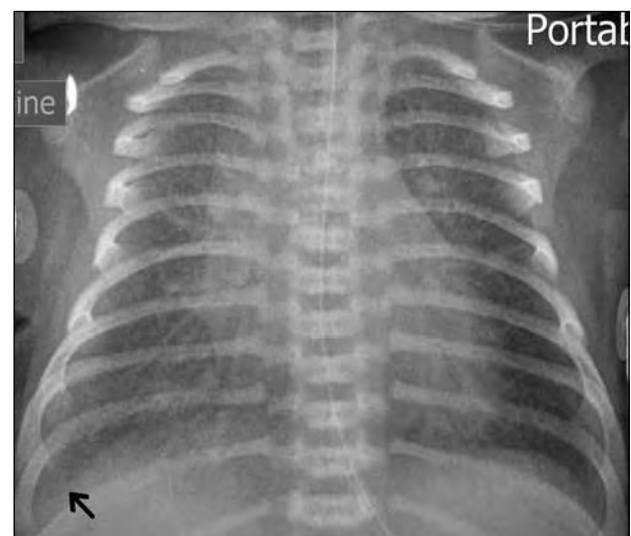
Pneumonia in a 38+4 weeks baby girl delivered by normal spontaneous vaginal delivery with clear liquor, presented with respiratory distress after birth. Chest X-ray on day 0 showing bilateral diffuse lung infiltrates, more on the right, with air bronchogram in the right lower lung zone and a small right pleural effusion (arrow). White cell count increased to $29.7 \times 10^9/L$ and C-reactive protein to 296.2 nmol/L. She was treated as pneumonia with antibiotics.
